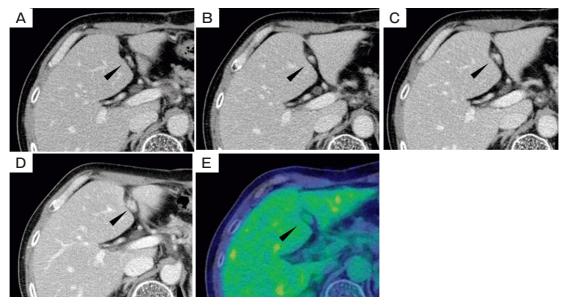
Serial contrast CT and additional PET/CT findings of the lesion of the ligamentum teres hepatis (black arrowhead shows the LTH). Contrast CT at 23, 39, 40 and 50 months after the gastrectomy (A-D) The additional PET-CT (E).
